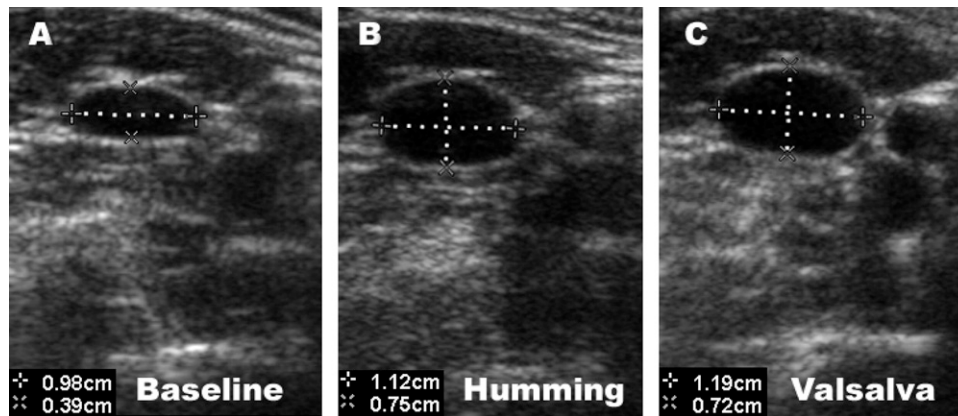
Changes in cross-sectional area as demonstrated by 2-dimensional ultrasonography during (A) rest, (B) loud humming, and (C) maximal Valsalva. Cross-sectional area was determined as a function of the major axes.
